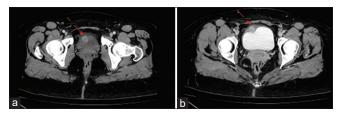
Computed tomography (CT) urogram of the reported case. CT urogram showed a 23 by 18 mm irregularly enhancing lesion (arrow) on the right side of the anterior wall of the bladder during arterial (a) and portal venous (b)
